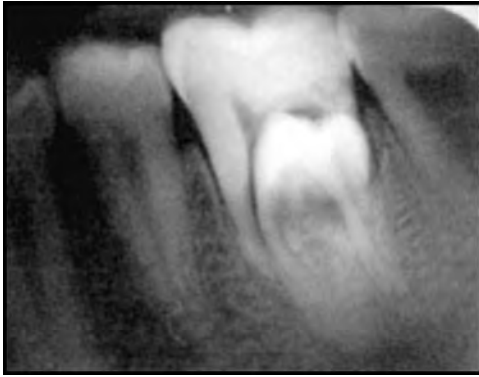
Tooth within a tooth appearance seen radiographically in a mandibular 1st permanent molar
